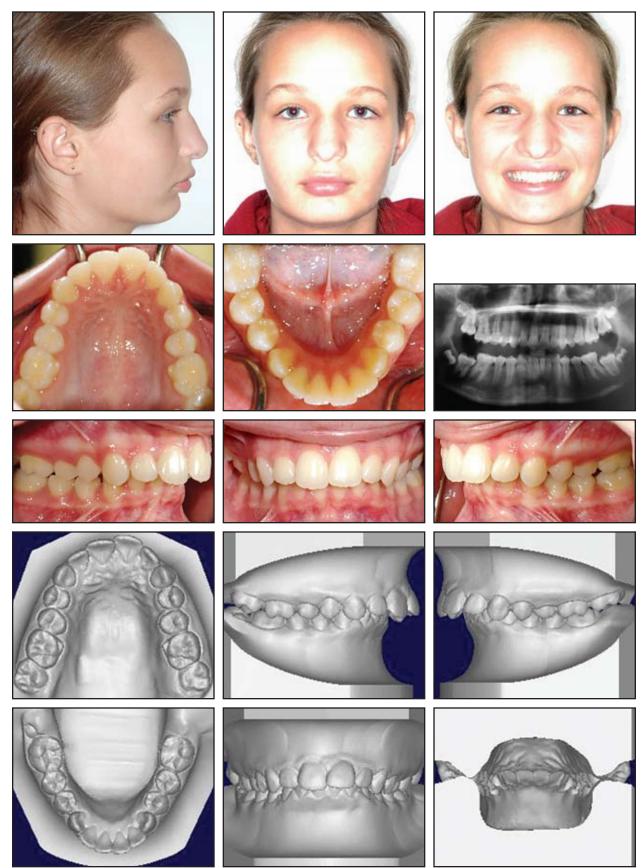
14-year-old female patient with Class II skeletal deep bite and excessive lower curve of Spee before treatment (panoramic radiograph taken six months before initial consultation; continued on next page).
